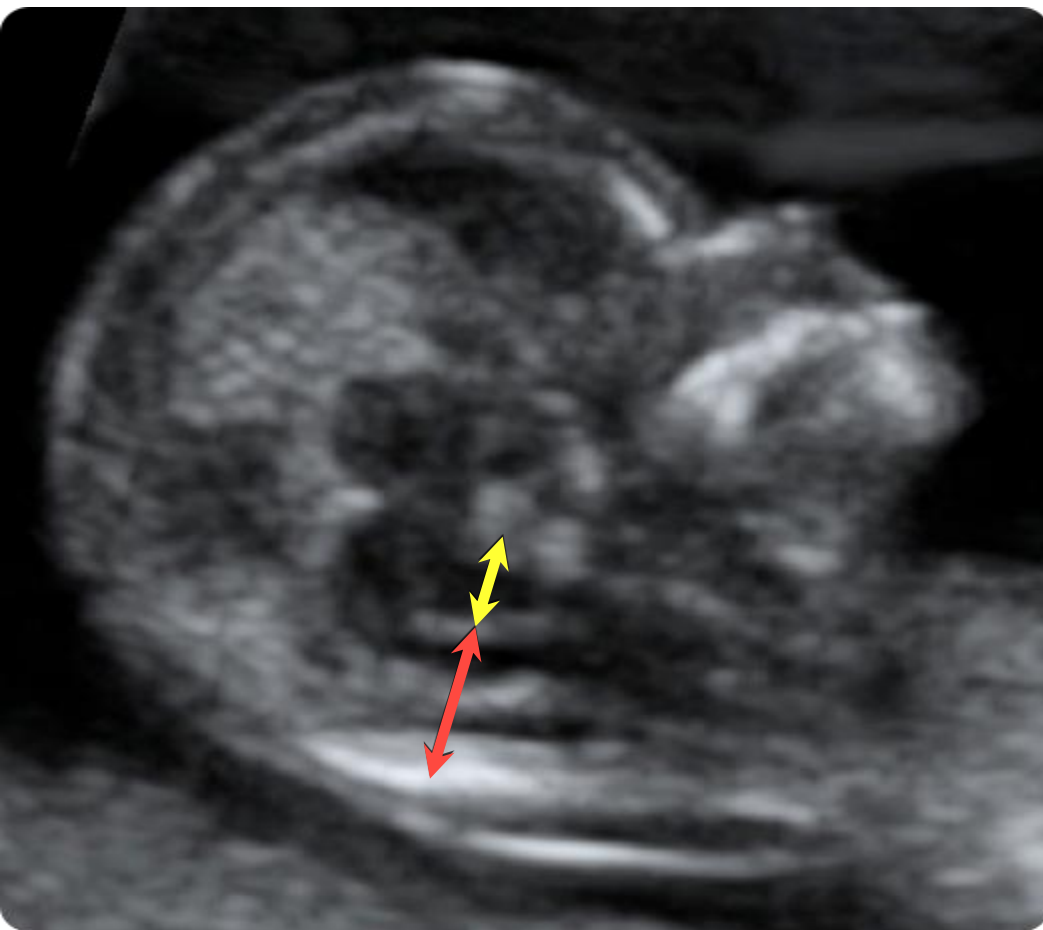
Case 1. (a) In the mid-sagittal view of the fetal face, obtained by transabdominal ultrasound, no typical intracranial translucency with clear borders is identifiable. The brainstem is thickened and the distance from the posterior border of the brainstem to the occipital bone is shorter than the brainstem diameter. (b) Subsequent examination of the spine, performed transvaginally, revealed a small lumbar spina bifida 5 mm in diameter (calipers) and, once the fetus had turned (c), the small myelomeningocele could be visualized in a coronal tangential plane.
